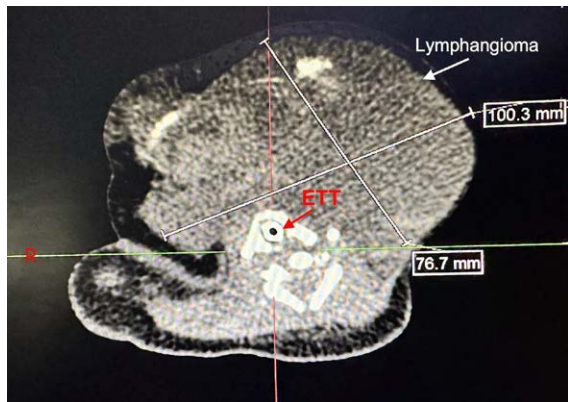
Transverse computed tomography scan of the neonate for further surgical evaluation. ETT, endotracheal tube.
